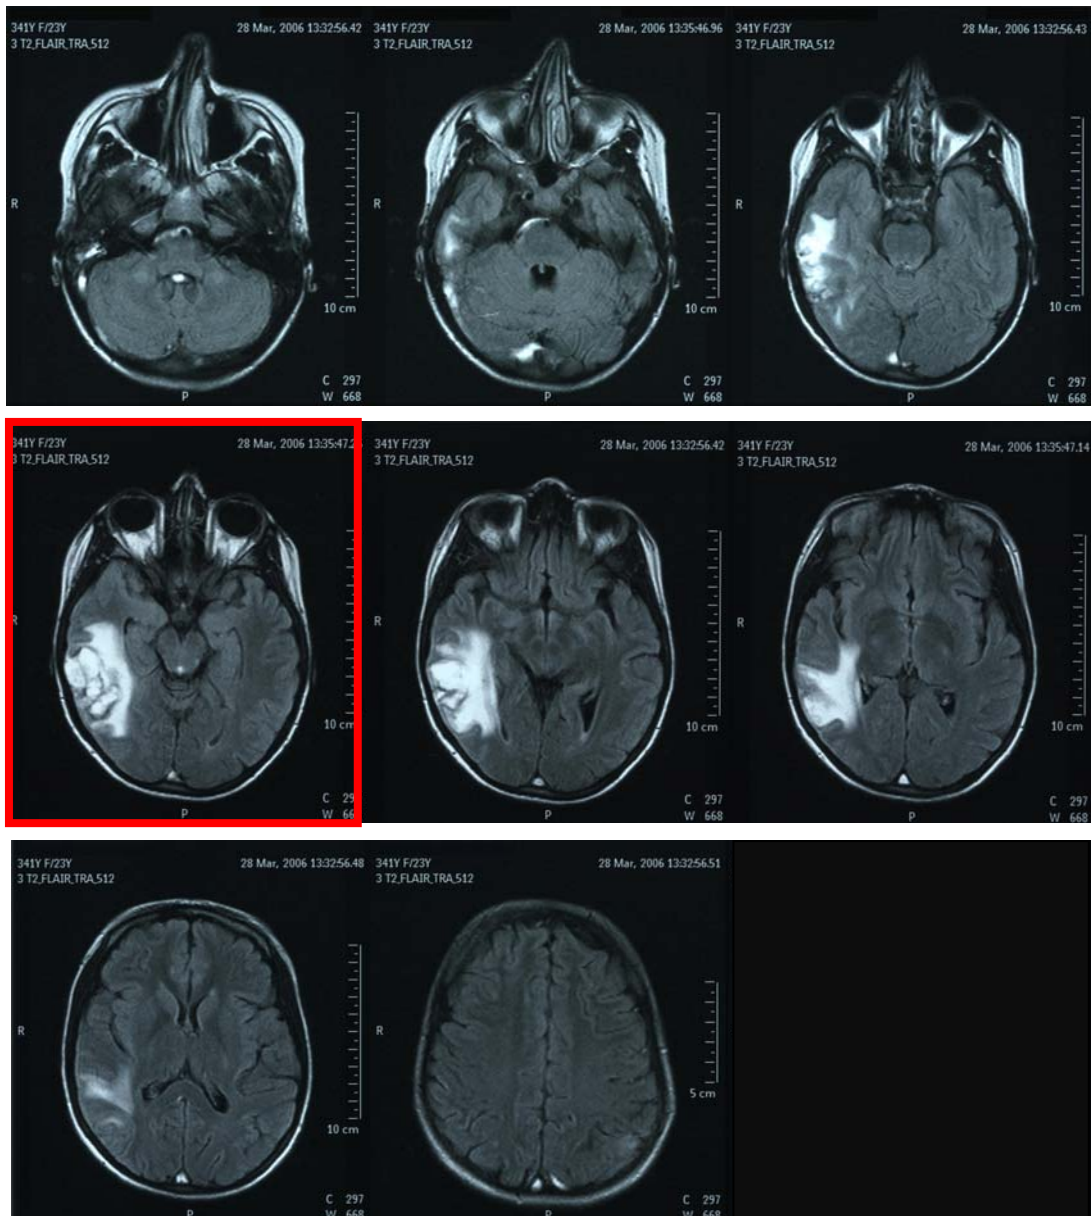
A typical MRI film showing the MR images that were evaluated to obtain the image where the infarct is best present
